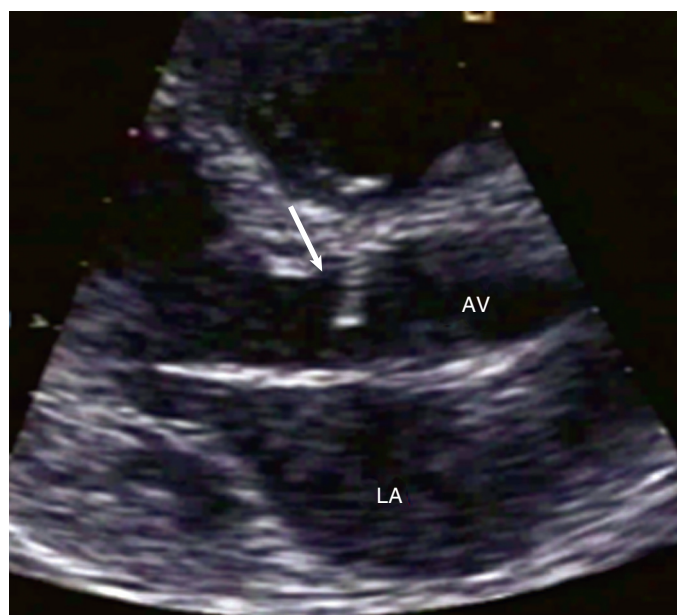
Nonstandard parasternal long-axis view demonstrating a sub-aortic membrane (arrow). The image is angled to show the membrane well with the result that the aortic valve (AV) is not well seen. LA = left atrium.
